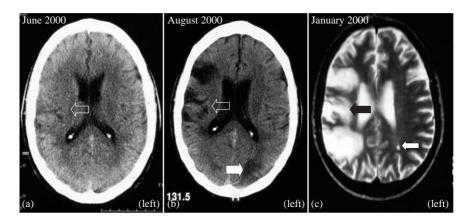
CT scans of a patient with severe headache (no seizures), high MCAV and severe hypertension seven days after left CEA. (a) Early CT scan after suffering a right carotid territory stroke in June 2000. Duplex showed a symptomatic right ICA occlusion and an asymptomatic left 90% stenosis. Note the evolving right MCA territory infarct (open arrow). (b) By August 2000, the patient had suffered left carotid territory TIAs and underwent a left CEA. Seven days post-operatively he was readmitted with severe left sided headache, elevated MCAV and hypertension. Note the old established infarct in the right hemisphere (open arrow) and the area of white matter oedema in the left posterior circulation (white block arrow). (c) T2 MR scan six months after (b). Note there is no evidence of infarction in the area corresponding to the white matter oedema noted in (b), but there is a small focal lesion at its periphery (small arrow).
